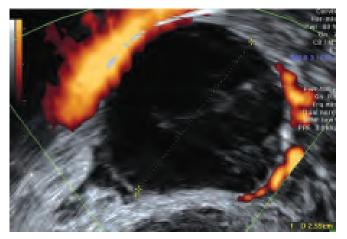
Power Doppler ultrasound demonstrates ring of angiogenesis surrounding the hemorrhagic cyst
